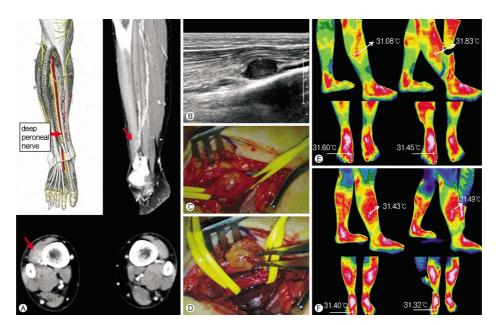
(A) A mass in deep peroneal nerve is identified through MRI scan of the lower extremity. (B) The size of mass is measured through ultrasound (about 2×2 cm). (C) Gross identification, the mass shaped like a pigeon egg. (D) Excised tumor mass with preserving normal nerve. (E) Preoperative IR thermography with and without compression test. (F) Postoperative IR thermography with and without compression test.
